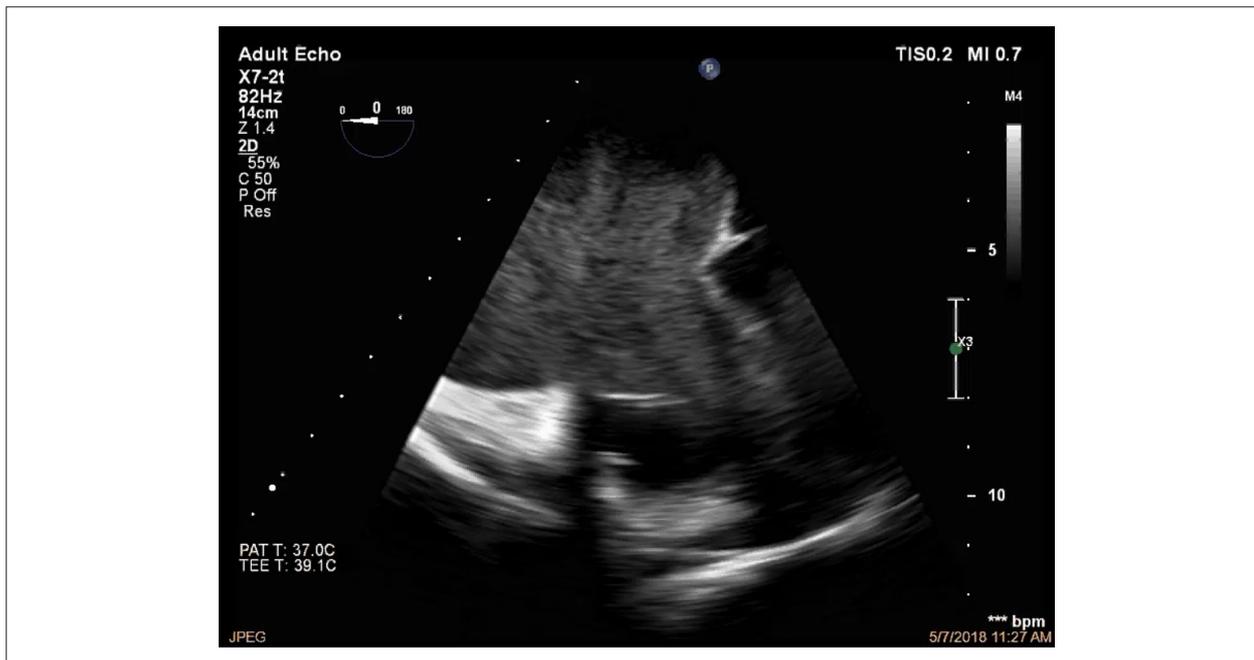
Transesophageal study showing severe right atrial increase and spontaneous contrast. SC: spontaneous contrast; RV: right ventricle.
